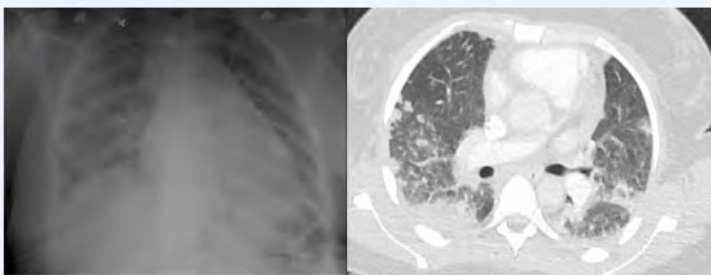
Chest radiograph on day of admission demonstrating diffuse bilateral opacities and enlarged cardiac silhouette. Computed Tomography with angiography demonstrating diffuse peripheral nodular opacities without evidence of pulmonary embolism and a large pulmonary artery.
